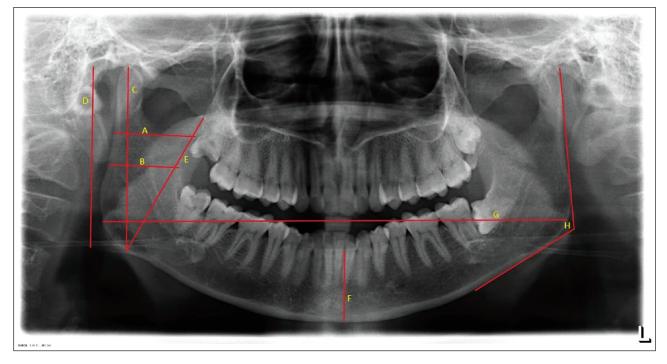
Orthopantomograph Showing all Eight Mandibular Measurements.
